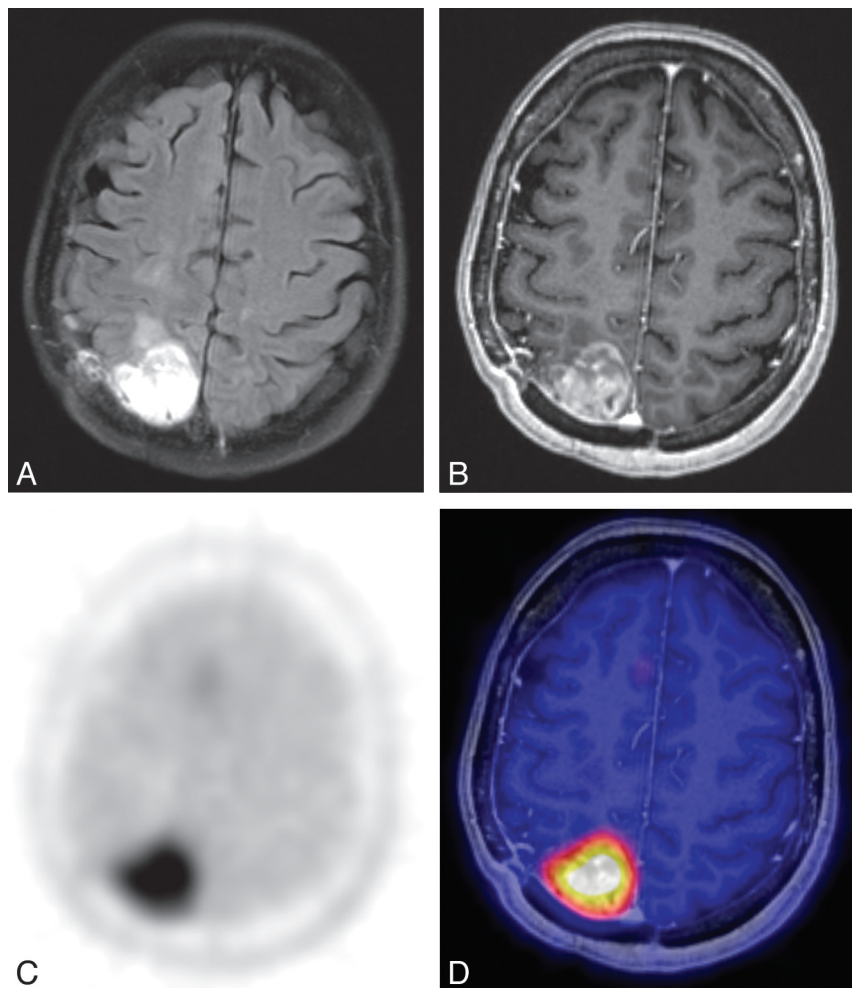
Example of combined FET-PET/MR imaging of a patient with HGG. A, T2-weighted FLAIR. B, T1-weighted image with Gd-DTPA. C, Static FET-PET. D, Fused image (B and C).
